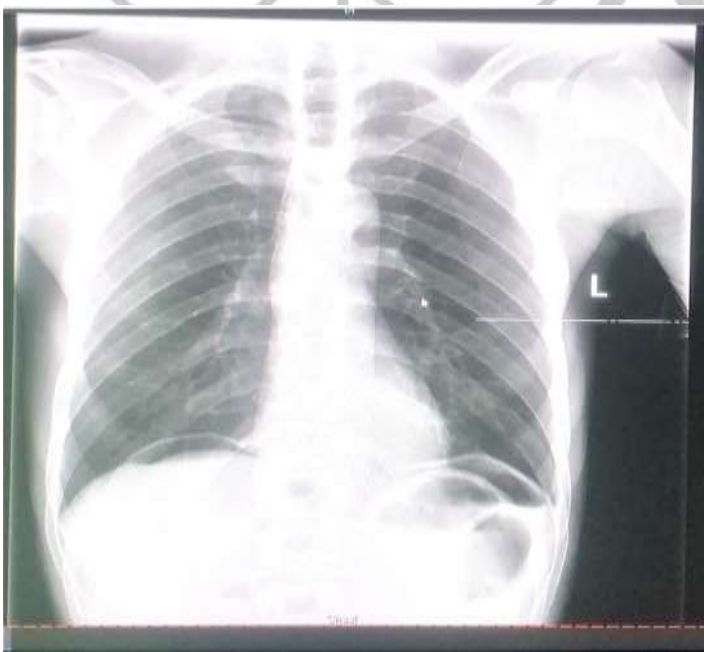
X-Ray Film of the Subject
